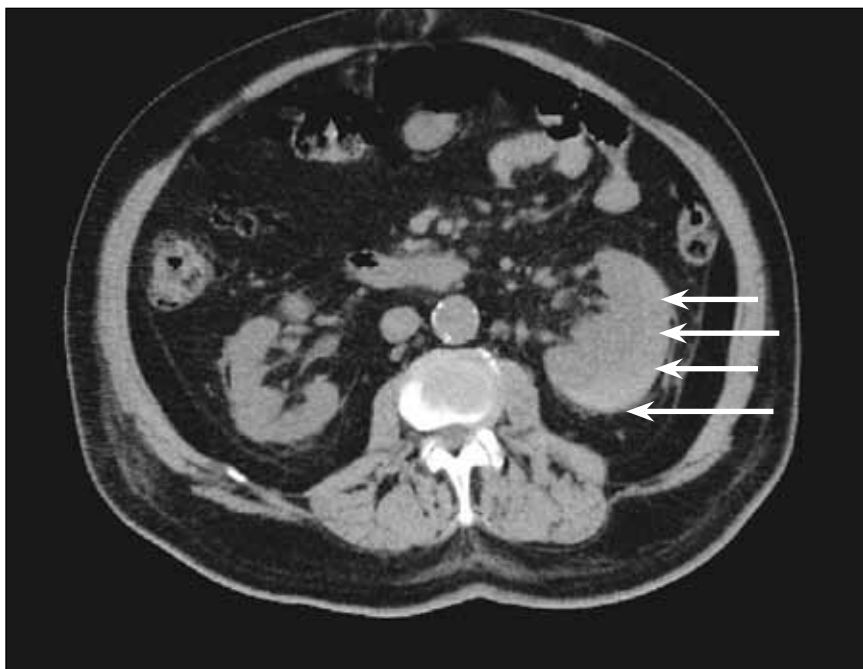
Noncontrast computed tomography slice of the abdomen. The white arrows indicate the area of the subcapsular hematoma as a high-attenuation mass.
